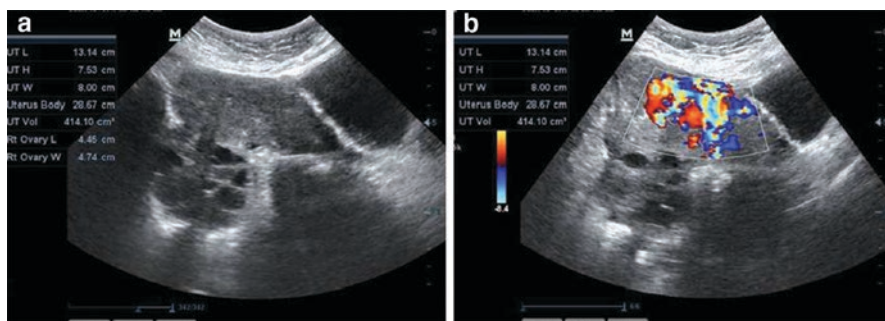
Case of GTN which presented with features of thyrotoxicosis. (a) Grey scale 2D ultrasonography showing uterus with theca-lutein cyst of ovary and (b) colour Doppler image showing increased vascularity inside the uterus
